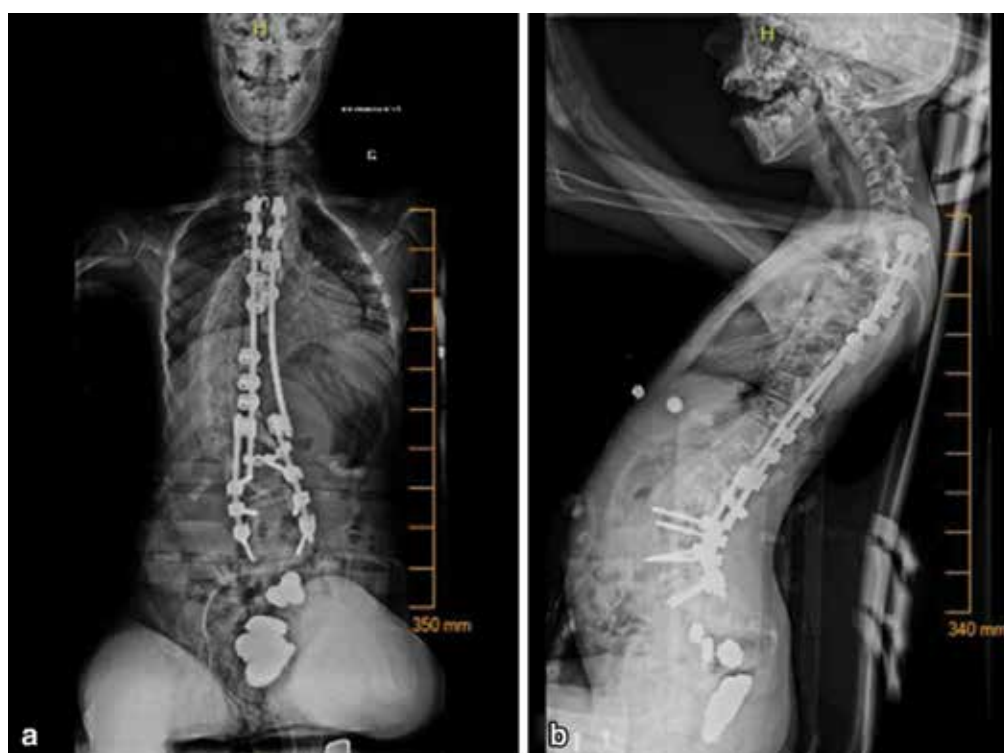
Postoperative radiograph showing T2–S1 fusion with hybrid instrumentation and a satisfactory curve correction.
